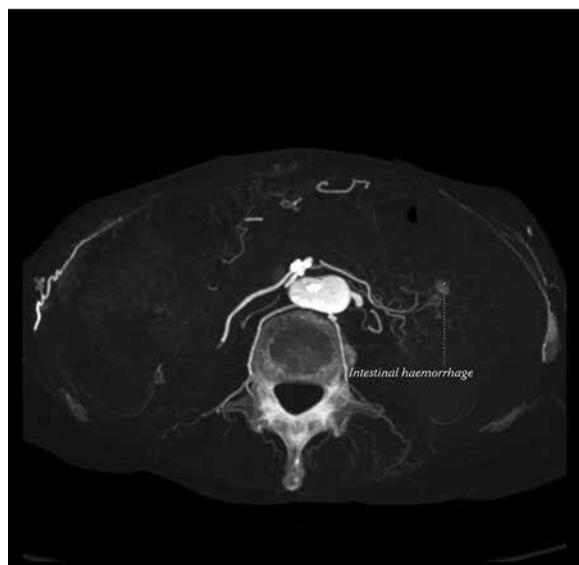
Axial angio-CT image (after administration of 8 mL of iodine contrast) demonstrating contrast extravasation.
